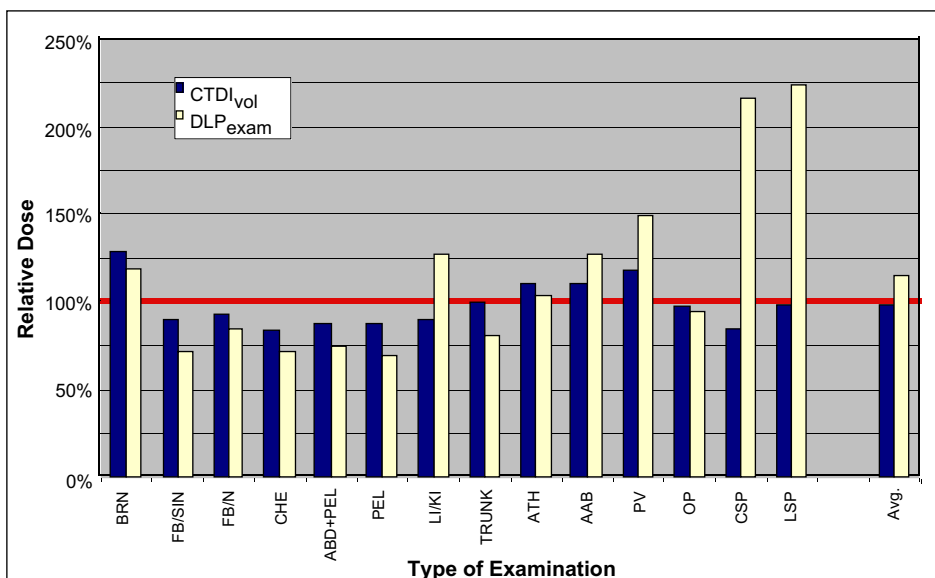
Relative dose levels of each particular type of examination, with 100% (red line) being the average value of the German '99 SSCT survey for the corresponding dose descriptor and type of examination. The most significant dose increases were observed for brain, liver/kidneys, CTA, and spine examinations (for abbreviations see tab. 1).
